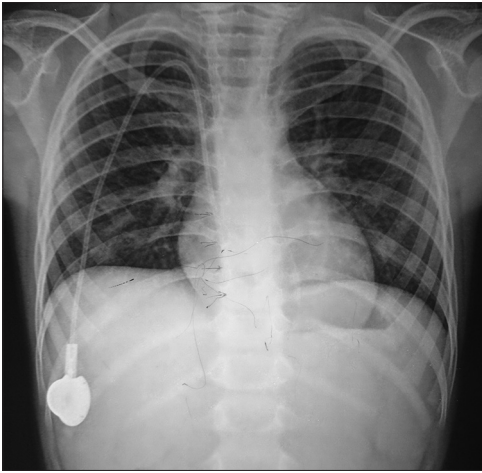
A plain radiograph with a chemoport *in situ*
